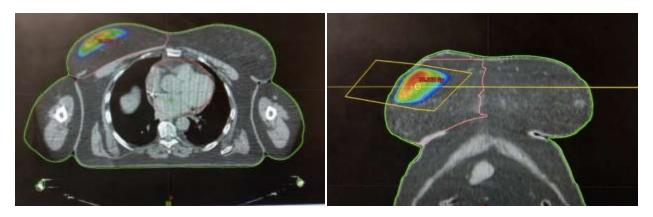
18FDG PET-CT showing a pathological hypermetabolic nodular focus in the right breast.
